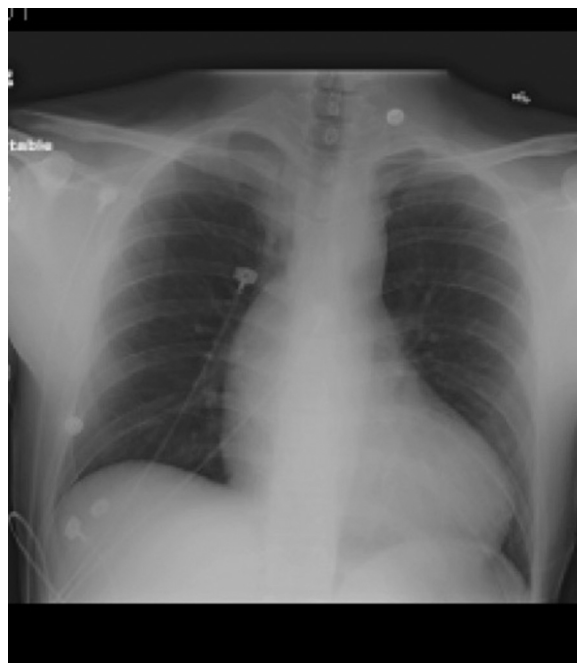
Portable chest radiograph showing enlarged cardiac silhouette and normal mediastinal contours.
